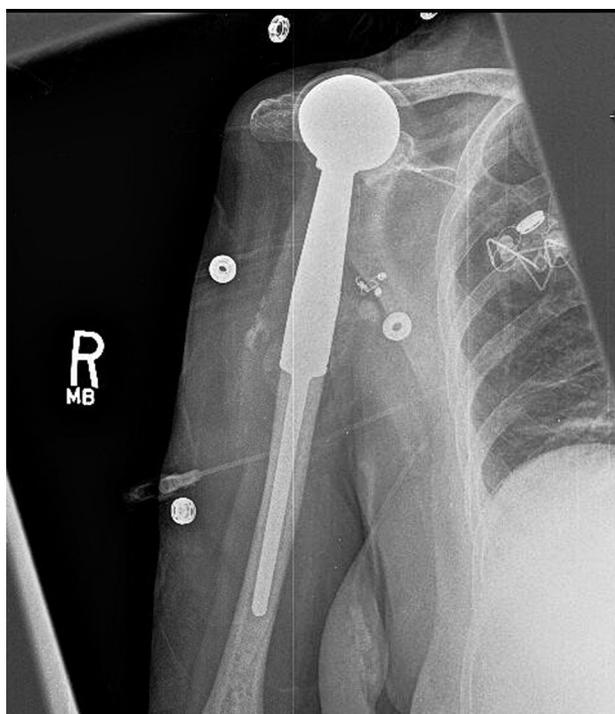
Radiographic example of anterior-superior escape in a patient with metastatic cancer treated with resection and proximal humeral hemiarthroplasty. In this example, a pseudocapsule has developed around the prosthetic humeral head. The prosthesis is easily palpable with a thin tissue layer between the skin and the implant. The patient has 30° of external rotation and 20° of internal rotation with the elbow by her side; forward elevation is severely limited at 20°.
